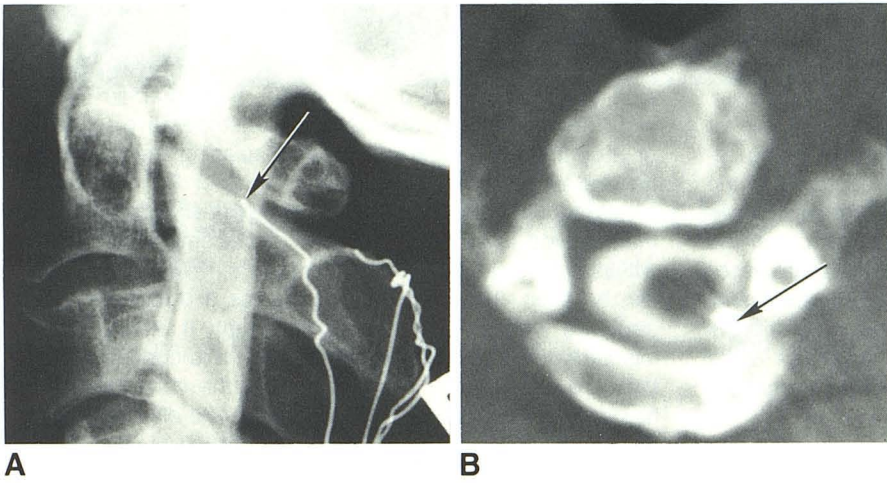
Initial metrizamide myelogram (A) and CT metrizamide myelogram (B) show broken surgical wire (arrow) with its tip extending anteriorly to enter dura at C1–C2 interspace and abut cervical spinal cord. Size of cord appears normal although it is positioned slightly to the left and posteriorly.
